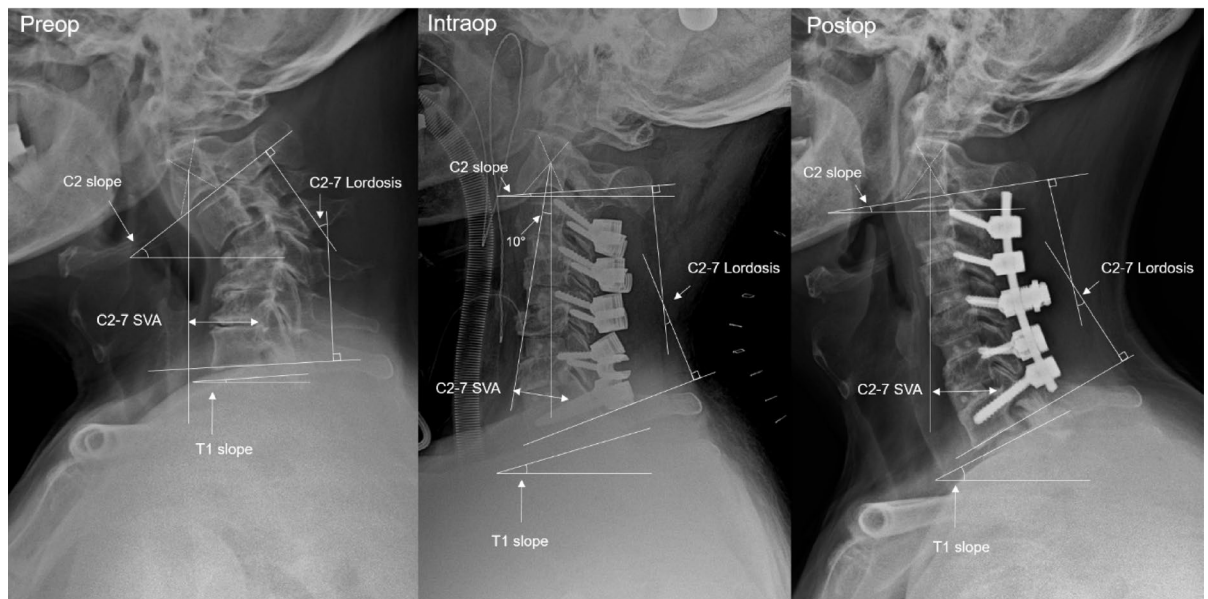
Radiographic measurements used in this study. The intraoperative film is taken with the patient in prone position with the table in 10° reverse Trendelenburg position. As a result, the axis is deviated by 10° causing 10° exaggerations of C2S and T1S.
